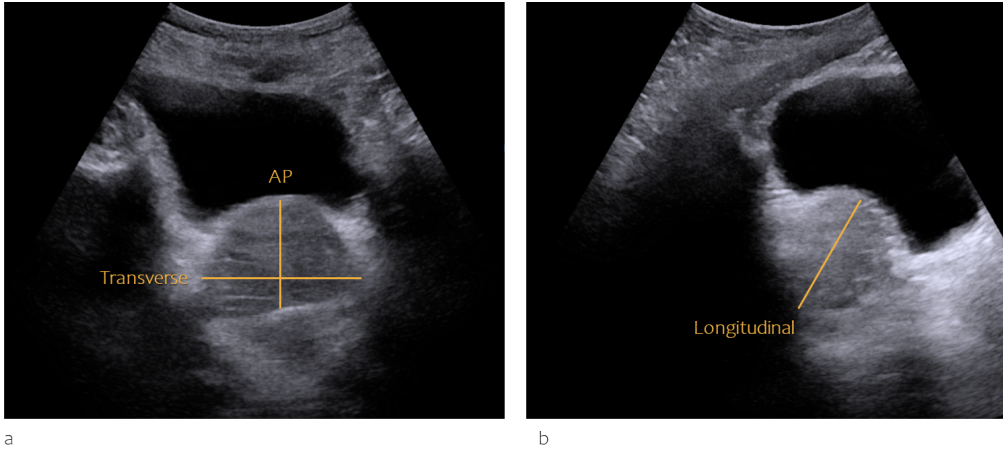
The prostate on transabdominal ultrasound (TAUS). a: Mid-axial TAUS image depicting the transverse diameter and the anterior-posterior (AP) diameter in yellow. b: Mid-sagittal TAUS image depicting the longitudinal diameter in yellow.
